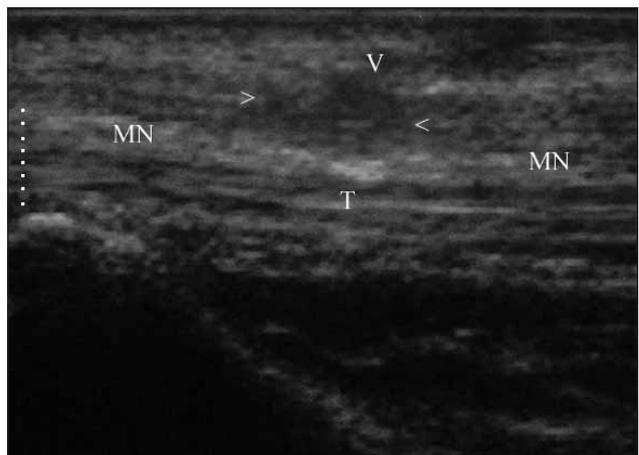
Ultrasonography shows median nerve, tendons, and scar formation around the nerve (MN: Median nerve, T: tendons, dotted line show carpal tunnel, arrows shows scar formation).
